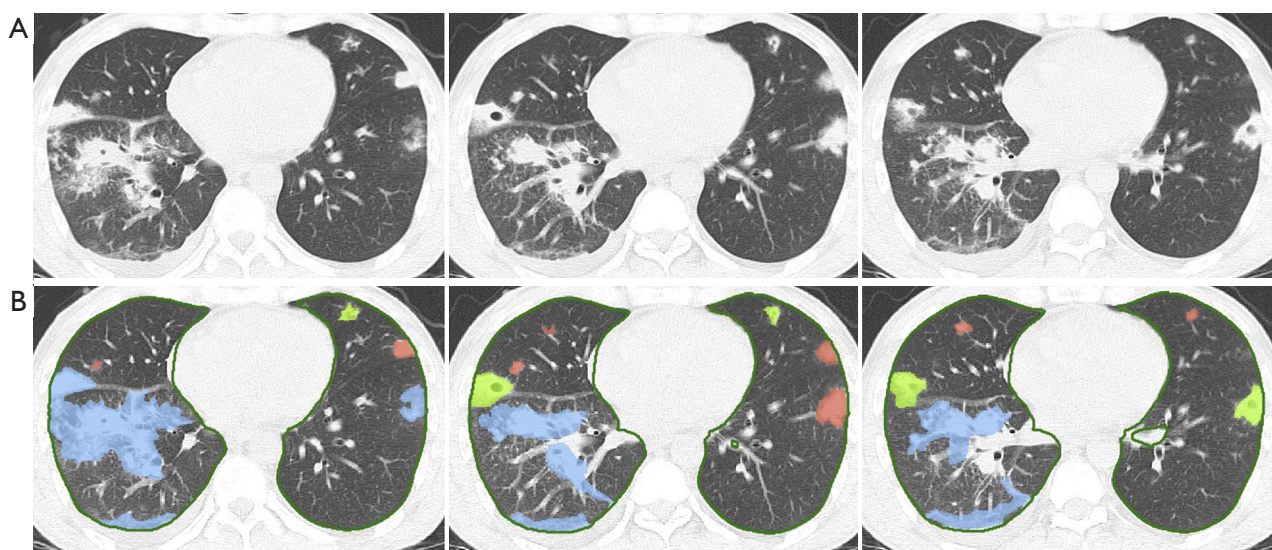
Examples of the lung segmentation (SCOAT-Net) and lesion annotation. For each pair of images, (A) the original computed tomography image and (B) the visualization of the lung segmentation and lesion annotation are presented (blue: consolidation; red: nodules; yellow-green: cavities). SCOAT-Net, spatial- and channel-wise coarse-to-fine attention network.
